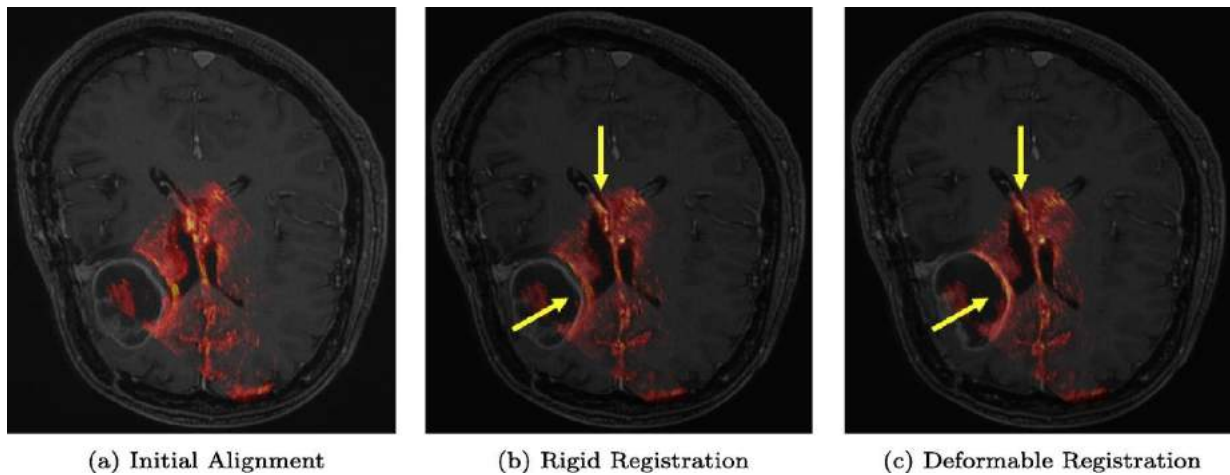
An example of anatomical deformation correction using deformable registration in an US-MRI image fusion approach [FWMN14].
